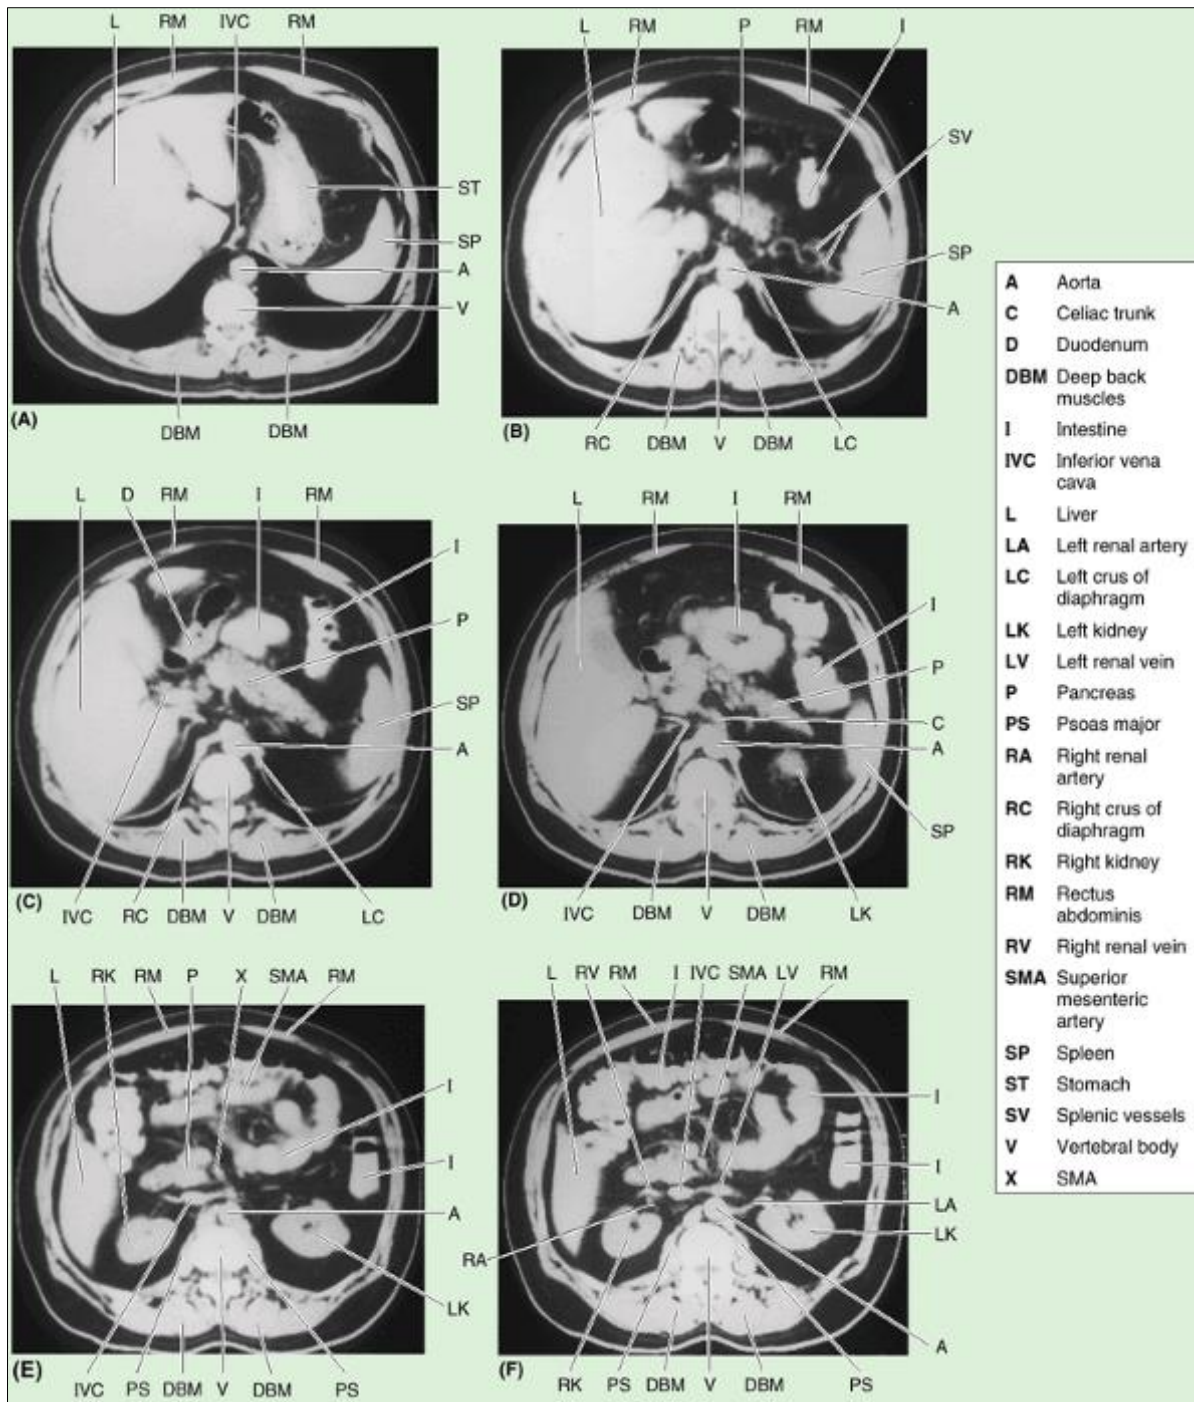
CT scans of abdomen at progressively lower levels showing viscera and blood vessels
